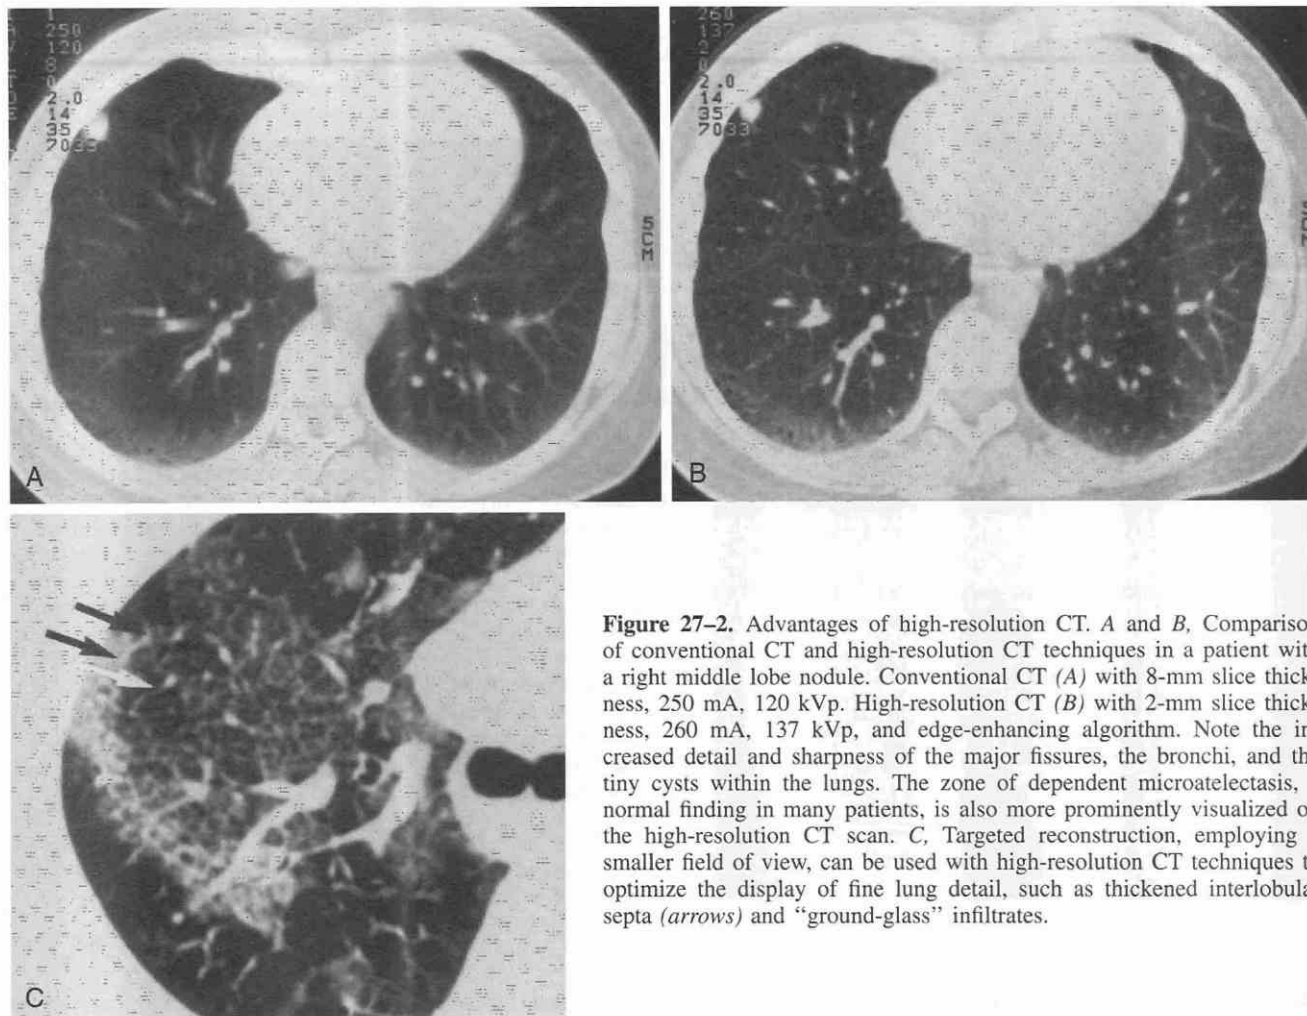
Advantages of high-resolution CT. A and B, Comparison of conventional CT and high-resolution CT techniques in a patient with a right middle lobe nodule. Conventional CT (A) with 8-mm slice thickness, 250 mA, 120 kVp. High-resolution CT (B) with 2-mm slice thickness, 260 mA, 137 kVp, and edge-enhancing algorithm. Note the increased detail and sharpness of the major fissures, the bronchi, and the tiny cysts within the lungs. The zone of dependent microatelectasis, a normal finding in many patients, is also more prominently visualized on the high-resolution CT scan. C, Targeted reconstruction, employing a smaller field of view, can be used with high-resolution CT techniques to optimize the display of fine lung detail, such as thickened interlobular septa (arrows) and “ground-glass” infiltrates.
